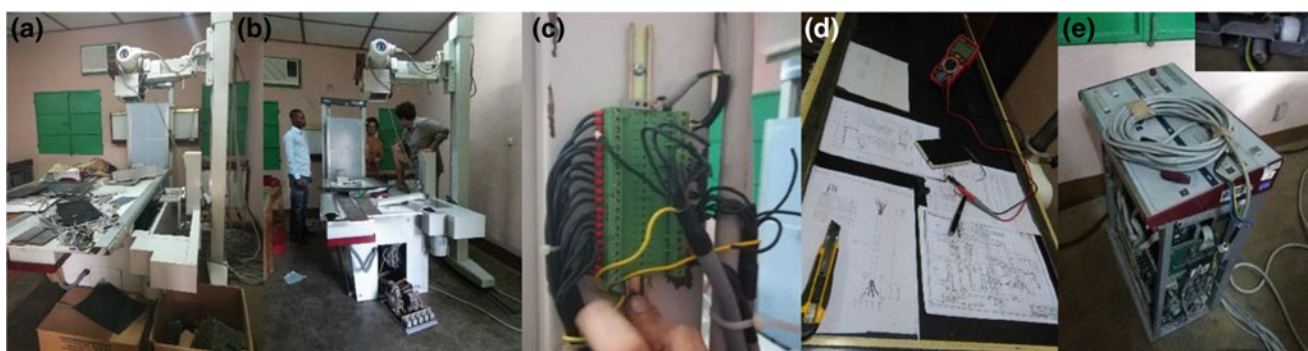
a, b and e show the donated X-ray machine; c shows one of the non-fused terminal blocks; d shows the set of instructions
